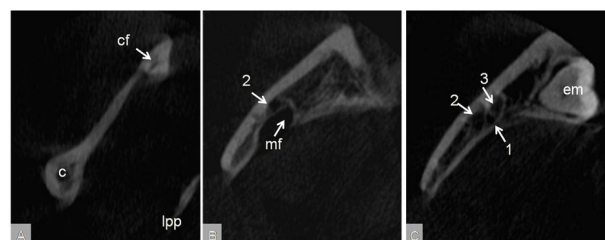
Axial Section of CBCT scan: A) showing c condyle; cf coronoid foramen; lpp lateral pterygoid plate. B) showing mf mandibular foramen; 2 accessory mandibular foramen. C) showing 1 mandibular canal; 2 & 3 accessory mandibular canals; em erupting third molar.
